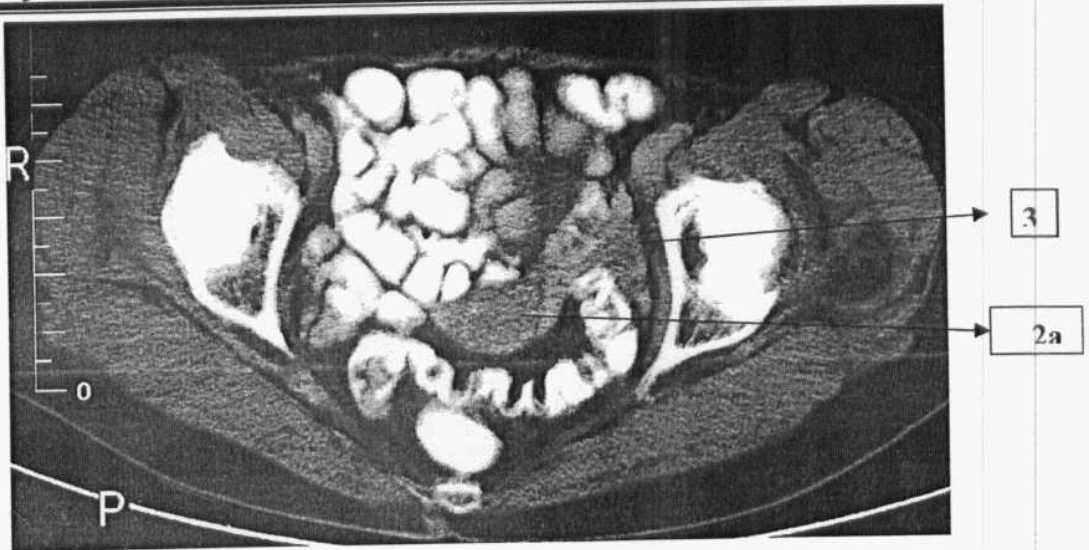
Axial CT of female pelvis
